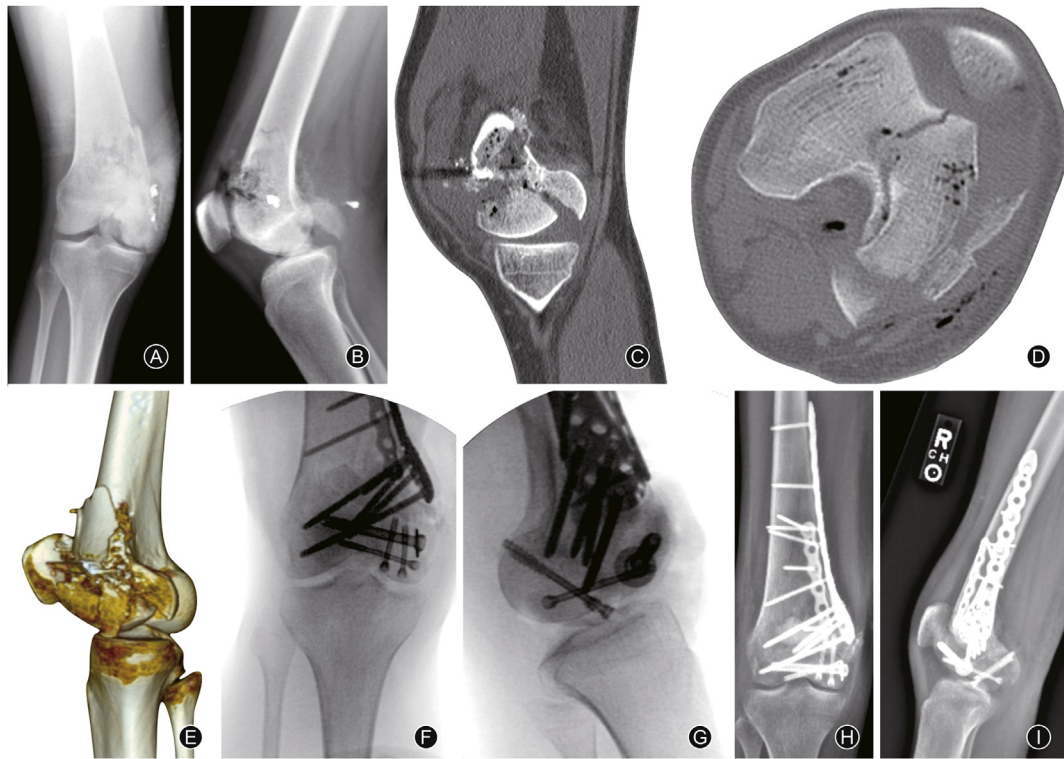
Case 1: use of a pre-contoured locking humerus plate to treat a complex medial femoral condyle open fracture caused by gunshot injury. (A) and (B): Distal femur in anteroposterior and lateral views after a gunshot injury, presenting a comminuted medial condyle fracture. (C-E): Sagittal, axial, and 3D CT-scan reconstruction views showing a Hoffa fracture with diaphyseal and intercondylar involvement, medially. (F) and (G): Cannulated screws support the fixation of the articular components. A proximal humerus plate (AxSOS 3 Proximal Humerus, Stryker®) used upside down improves fixation and allows for locking screws crossing the fracture, therefore purchasing into the lateral condyle. (H) and (I): Anteroposterior and lateral views after healing, exhibiting a well-maintained joint line.
